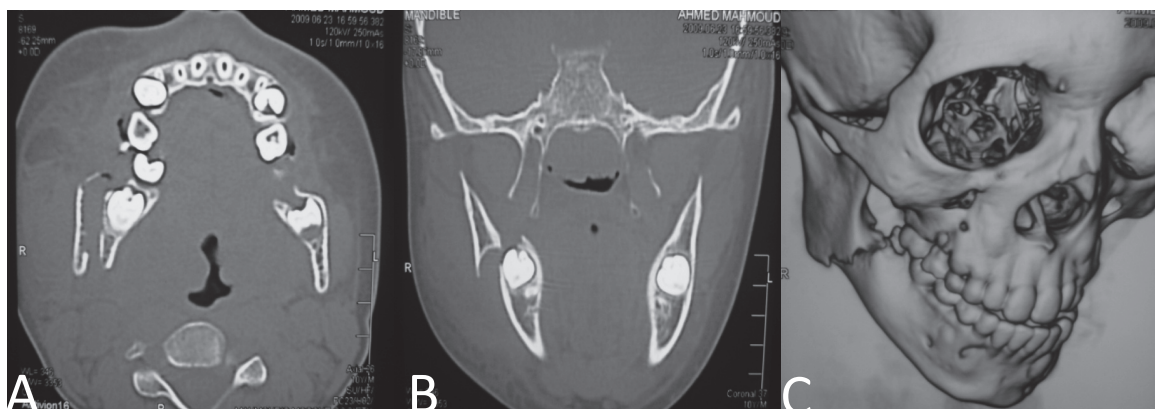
(A) Axial CT scan bone window showing fracture of the right angle of the mandible with anterior displacement of the ramus. (B) Coronal CT scan bone window showing fracture of the right angle of the mandible with medial displacement of the body of the mandible. (C) R3D-CT scan showing fracture of the right angle of the mandible starting from the distal surface of the lower right wisdom tooth and extending posteriorly and inferiorly till the angle of the mandible.
